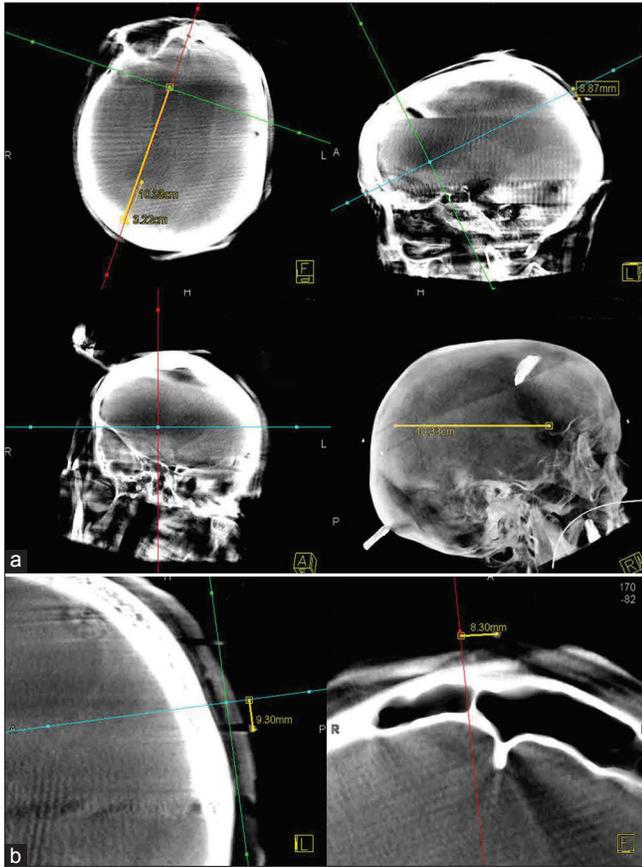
(a) Planning CB-CT produces three-dimensional surgical planes (axial, coronal, and sagittal) and a three-dimensionally reconstructed image, which helps determining the site of the burr hole and the direction and depth for catheter insertion. (b) External copper markers placed on the glabella and the conventional entry point can be detected with planning CB-CT to allow correction of the true external landmark relative to the external copper marker based on visual inspection
